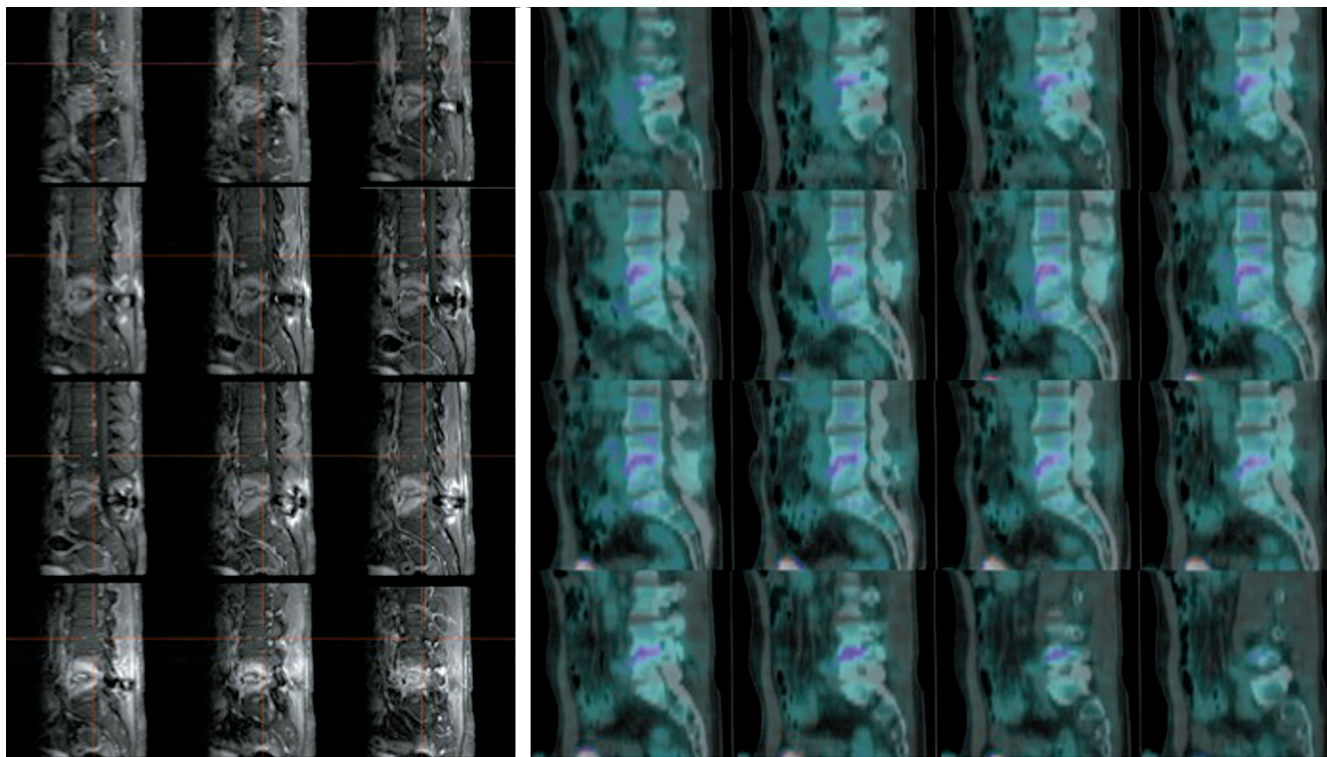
A case of suspected SD. Left panel: sagittal MRI images showing oedema of L4-L5 highly suggestive of spondylodiscitis. Right panel: same patient studied with [¹⁸F]FDG PET/CT showing very moderate uptake of the radiopharmaceutical in L3-L4, this excluding the presence of an infectious process.
